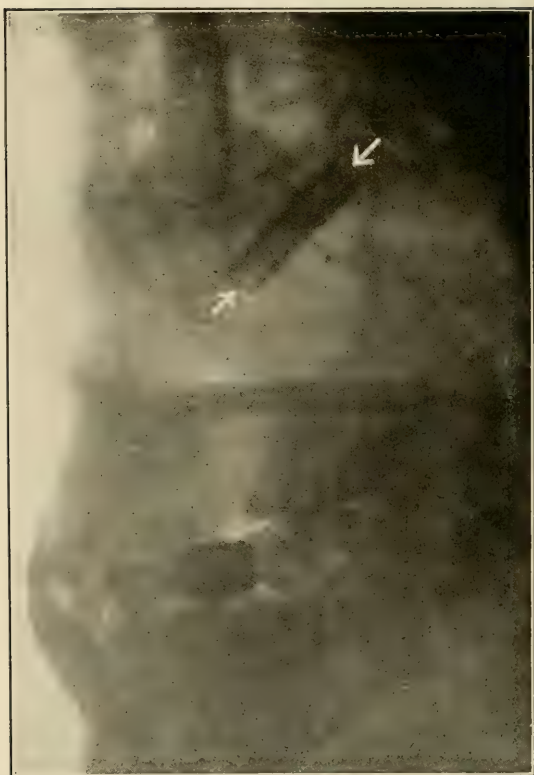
The arrows point to a piece of rubber tubing in the antrum. (Radiograph by Pancoast, of Philadelphia.)
